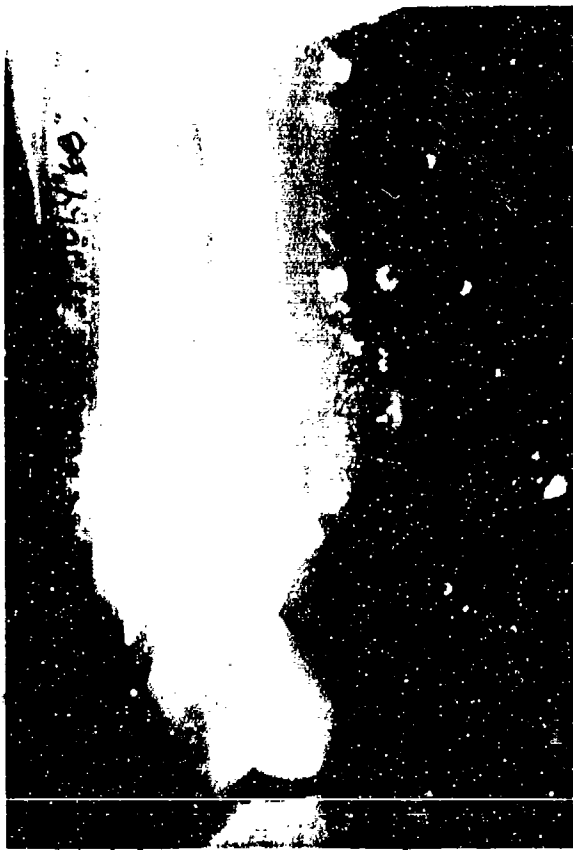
The roentgenogram of the injury shown in Figure 4-44. Secondary missiles of bone and lead in conjunction with temporary cavitation caused the huge wound of exit. This injury is an example of an "explosive wound" such as those first described in the nineteenth century when conoidal bullets were introduced.
